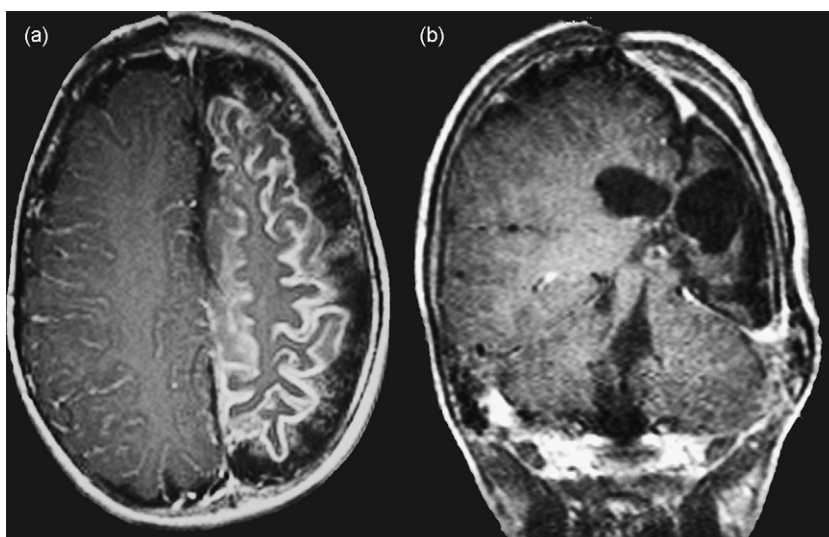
Sturge–Weber disease. (a) Preoperative Gadolinium-enhanced Axial FSE T1w MR image demonstrates enhanced cortical gyri of the atrophic left cerebral hemisphere. (b) Postoperative (hemidecortication) coronal FSE T1w MR image after iv gadolinium injection confirms the removal of the affected cortex and demonstrates the contralateral shift of the preserved normal hemisphere toward.
